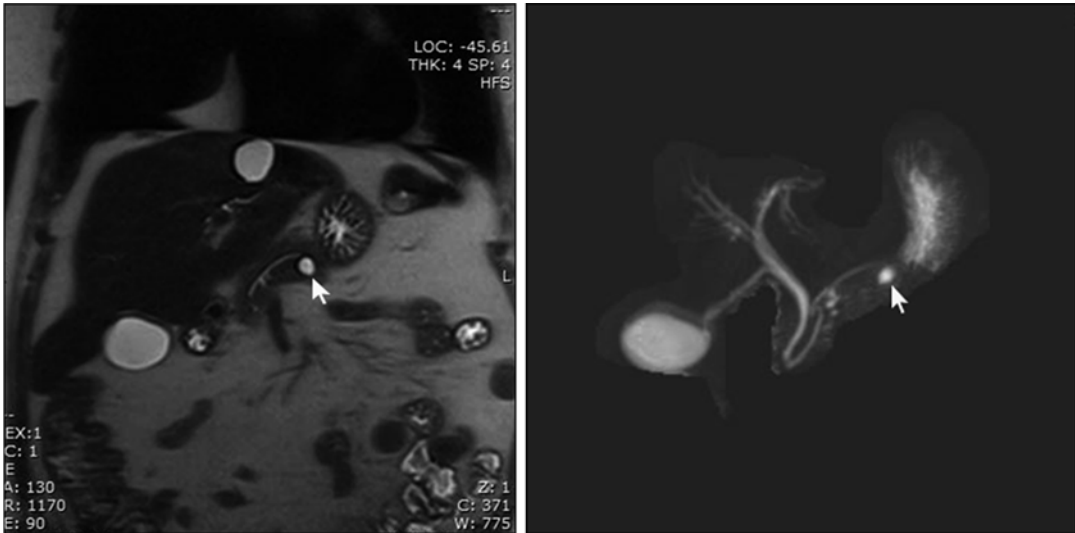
Radiological characteristics of side-branch IPMNs. (a) MRI of a 35-year-old asymptomatic female patient shows a 9-mm cystic lesion (*white arrow*), in close
